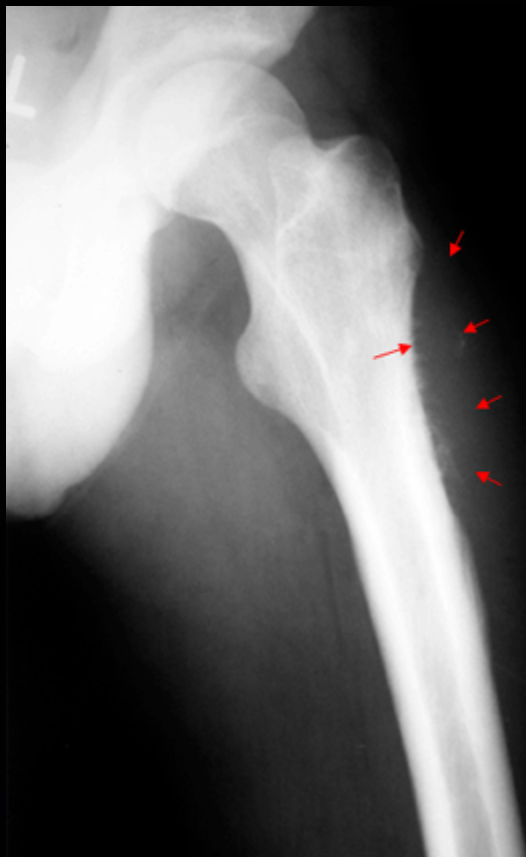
X-ray (radiograph) of thighbone (femur) with Ewing's sarcoma.
